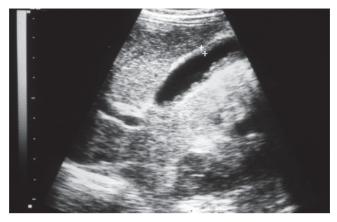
Ultrasound scan appearance of gallstones with acoustic shadows. The gallbladder wall (marked with crosses) is irregular and thick, consistent with chronic cholecystitis.
